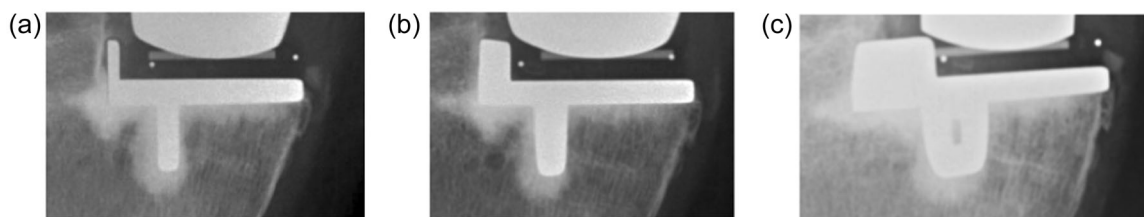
Three progressively rotated anteroposterior knee radiographs from a patient, demonstrating how rotation can cause masking of a radiolucency adjacent to the tibial wall. Rotation ratio for (a) 32%, (b) 82% and (c) 223%.
